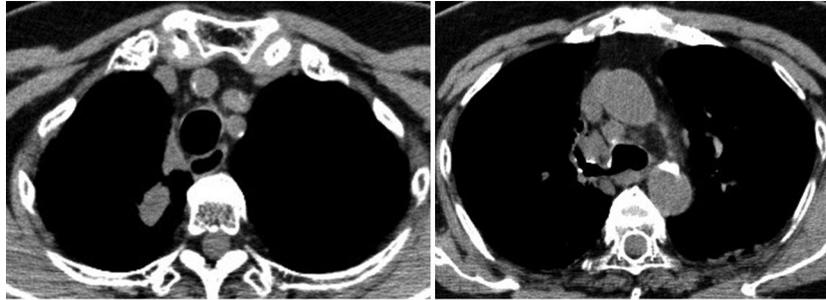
Chest computed tomography taken 7 years and 7 months after the start of small cell lung carcinoma treatment revealed small nodules in both lungs and swelling of the lymph nodes in the ipsilateral mediastinum.
